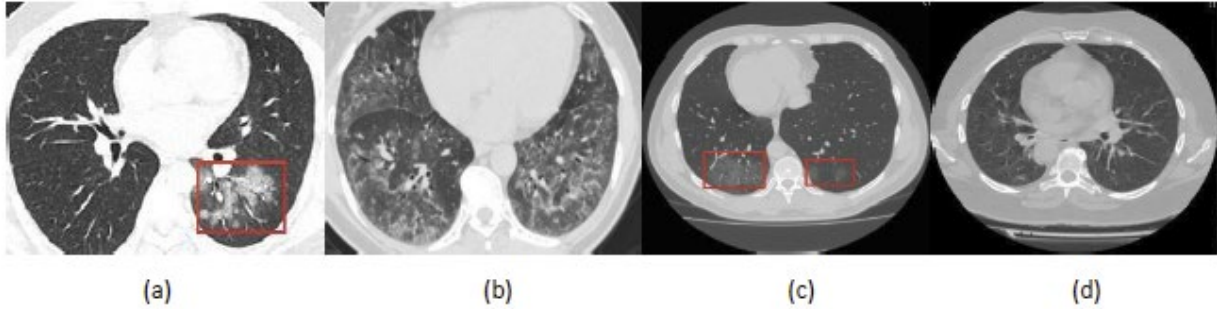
Examples of chest CT scans of patients from UCSD-AI4H and MosMedData; the red bounding boxes (added by authors) enclose the COVID-19 diseased regions. (a) the COVID-19 positive class from UCSD-AI4H, (b) the COVID-19 negative class from UCSD-AI4H, (c) the COVID-19 positive class from MosMedData, (d) the COVID-19 negative class from MosMedData.
